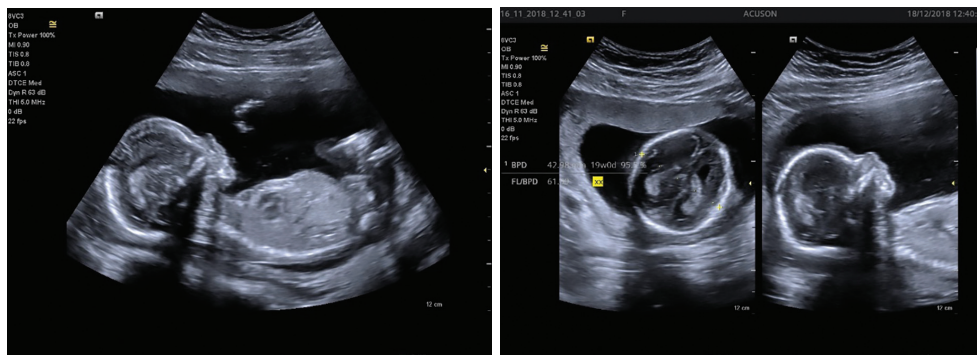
Transvaginal ultrasound, 2D sonography is a screening of the first trimester of pregnancy /fetal anatomy, section of the head with the structure of the brain, nuchal transparency, facial bones and nasal axis/
